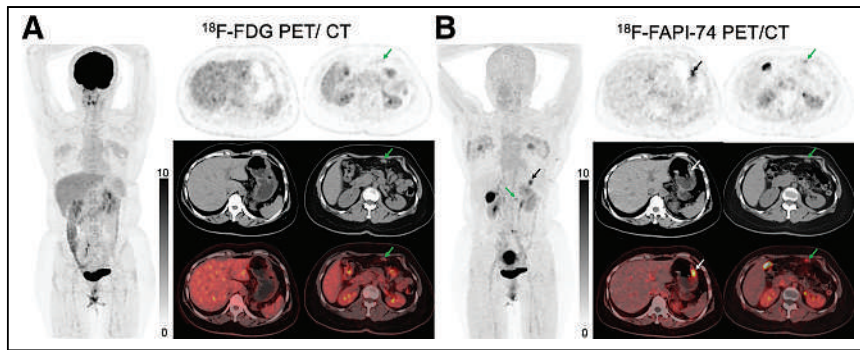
Representative case of gastric cancer detected using ^{18}F -FAPI-74 PET/CT but missed using ^{18}F -FDG PET/CT. (A) 38-y-old woman with pathologically confirmed gastric signet ring cell carcinoma underwent initial staging using ^{18}F -FDG PET/CT, which shows involved periintestinal LNs (arrows) only in CT image. (B) ^{18}F -FAPI-74 PET/CT shows intense radiotracer uptake in primary lesion (both black and white arrows) and periintestinal LN (green arrows). Subsequent percutaneous biopsy in this LN confirmed metastatic disease (focal activity above right kidney indicates physiologic gallbladder uptake).
